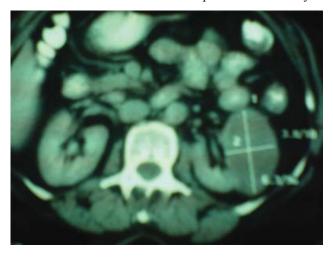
CT image shows solid mass with enhancement and RCC diagnosis
